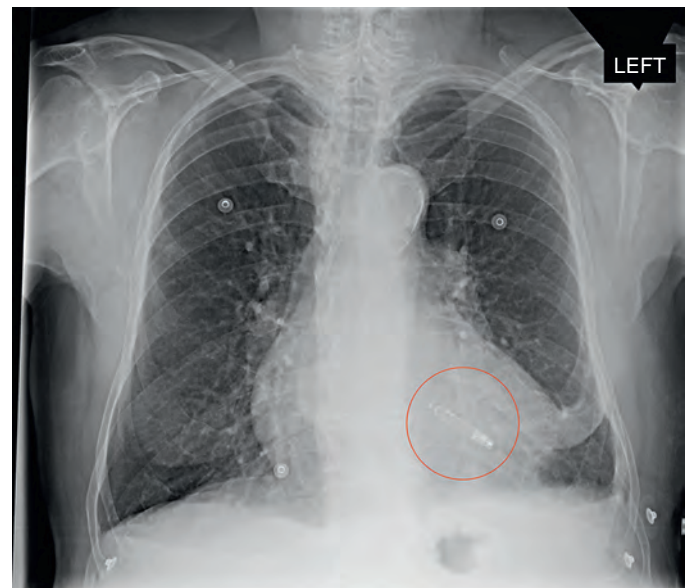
The St. Jude Nanostim leadless intracardiac pacemaker. A leadless pacemaker is shown in the right ventricle (circle) on this posteroanterior chest film. Leadless pacemakers are currently approved for implant in several countries outside of the United States. (X-ray image courtesy of Vivek Reddy, MD, Icahn School of Medicine at Mount Sinai, New York, NY.)
